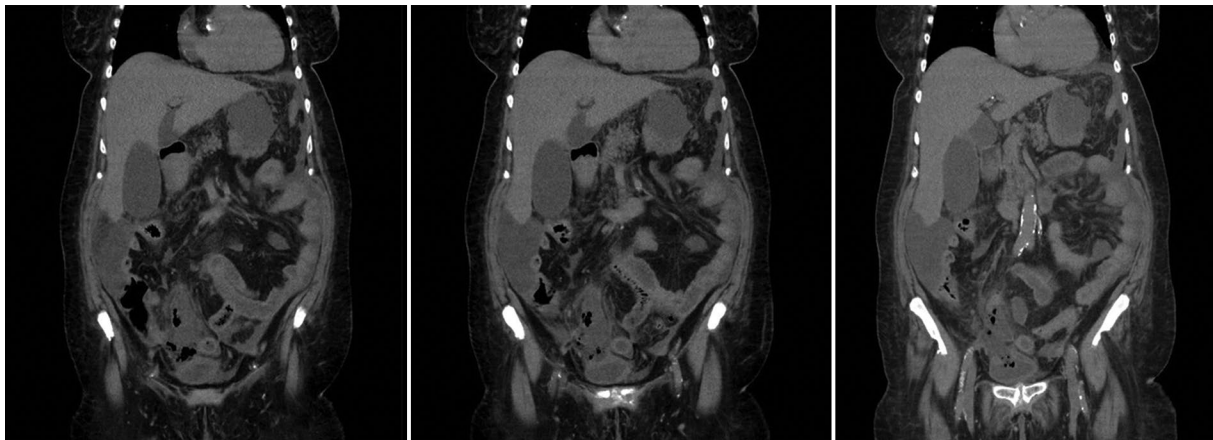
Findings of the contrasted abdominal computed tomography, coronal view.
